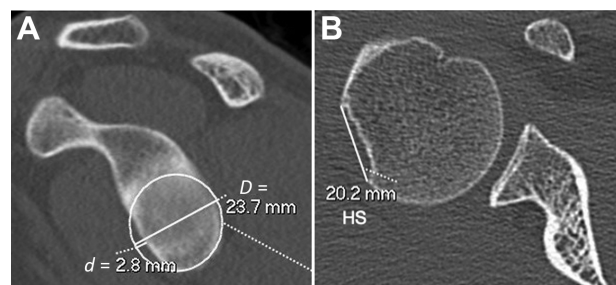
Evaluation of the glenoid track. (A) Measurement of the glenoid diameter (D) and bone loss (d) using the best-fit circle technique on a sagittal CT scan. (B) Measurement of the HS length on an axial CT scan from the medial edge of the HS lesion to the insertion of the rotator cuff. According to the formula $Glenoid\ track = 0.83 * D - d$, the glenoid track in this patient was 16.9. The HS lesion length was 20.2 mm. Since the HS lesion was larger than the glenoid track, the lesion was classified as off-track. CT, computed tomography; HS, Hill-Sachs.
